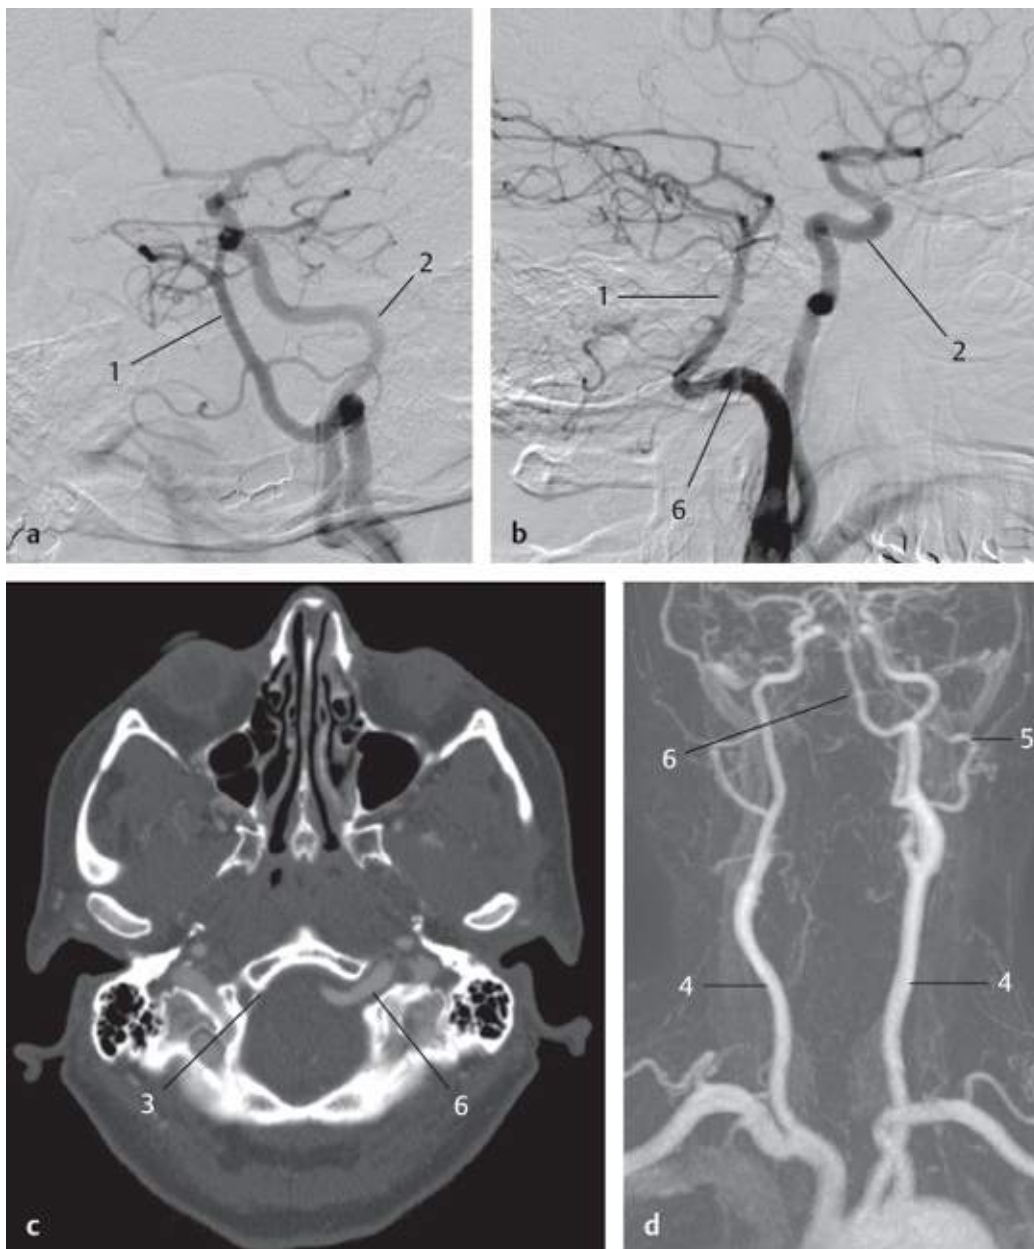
Persistent hypoglossic artery. DSA, oblique view (a) and lateral oblique view (b); CTA at the level of the hypoglossic foramen (c); and contrast-enhanced MRA (d). 1 Basilar artery; 2 internal carotid artery; 3 foramen of the right hypoglossic nerve; 4 common carotid artery; 5 occipital artery; 6 persistent hypoglossic artery.
